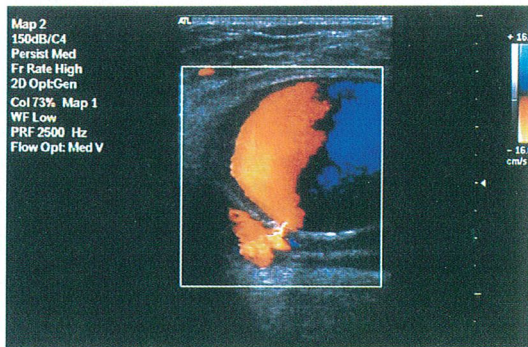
A pseudoaneurysm originating from the superficial femoral artery is seen in the color Doppler examination.
